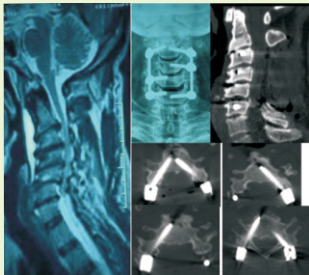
Preoperative MRI showing C3 to C6 compressive myelopathy and Kyphosis. Postoperative images on the right showing decompressive Laminectomy with kyphosis correction using cervical pedicle screws.
